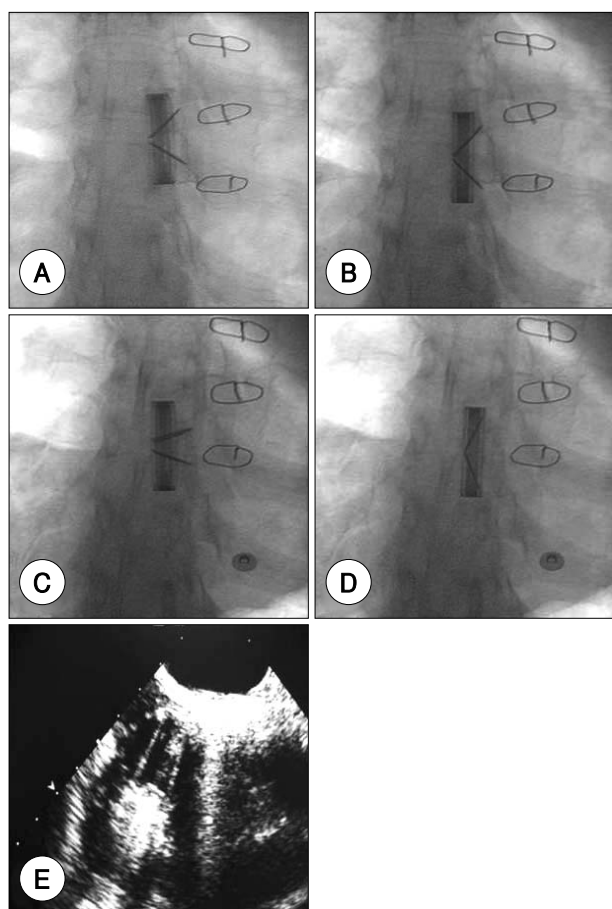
Cine-fluoroscopic and TEE findings before and after thrombolysis. On cine-fluoroscopy, the TV motion was limited and almost fixed in diastole (A) and systole (B). 24 hours after performing thrombolysis with urokinase, the prosthetic tricuspid valve leaflet had no limitations of motion during diastole (C) and systole (D). On the following TEE, the TV leaflets moved without any limitation, and any thrombus around the TV was not found (E). TEE: transesophageal echocardiography, TV: tricuspid valve.
